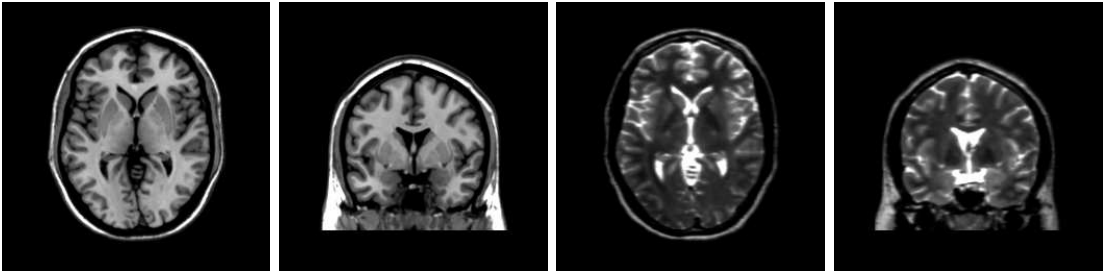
T1- and T2-weighted MR images. Left to right: T1 axial and coronal images (light regions visualize locations of fat), T2 axial and coronal images (light regions visualize locations of water).
